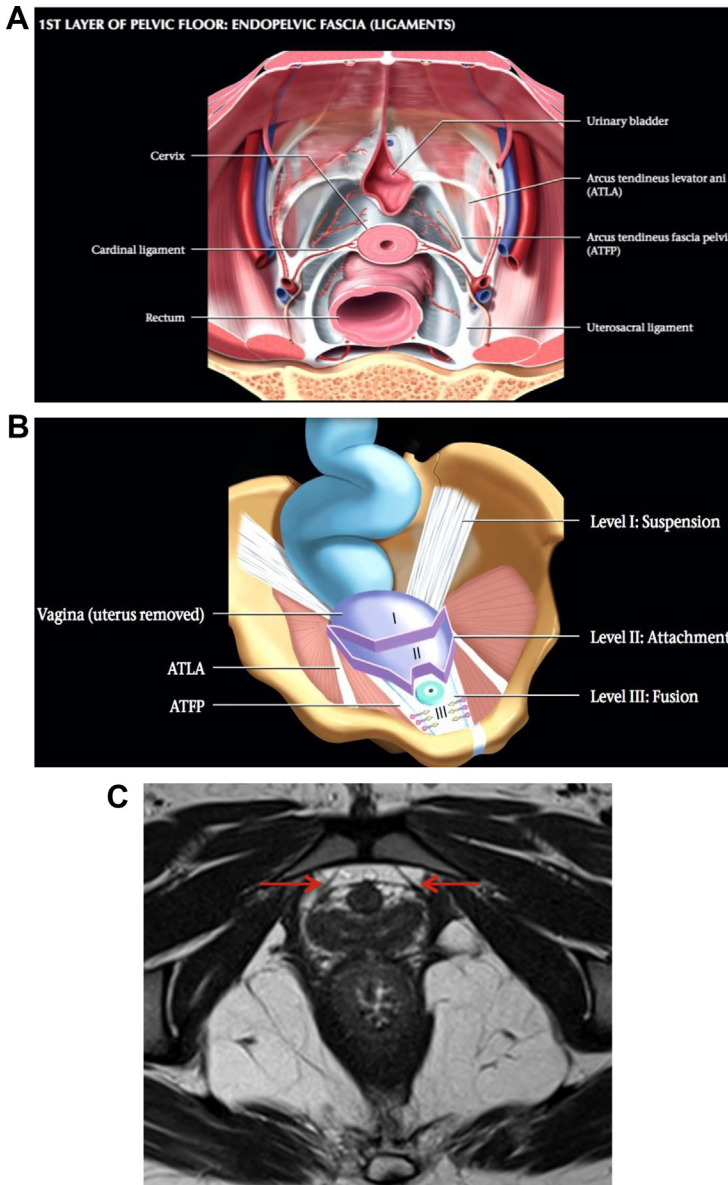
(A) Overview of the pelvis shows the fascia with the bladder, cervix, and rectum cut away. Endopelvic fascia is a continuous adventitial layer, covering the pelvic diaphragm and viscera. It is a complex network of connective tissue composed of collagen, fibroblasts, elastin, smooth muscle cells, and neurovascular bundles. Ligaments are a more well-defined aggregate of connective tissue. (B) The type of support the vagina receives at each level (uterus removed). In level I (suspension), the paracolpium suspends the vagina from the lateral pelvic walls. Fibers of level I extend both vertically and posteriorly toward the sacrum. In level II (attachment), the vagina is attached to the arcus tendineus fasciae pelvis and the superior fascia of levator ani. In level III (fusion), the vagina, near the introitus, is fused laterally to the levator ani. (C) Axial oblique T2WI TSE MR image shows the arcus tendineus fascia pelvis (ATFP) (arrows) on either side of the symphysis pubis. (From [(El Sayed RF. Overview of the Pelvic Floor. In: Shaaban AM, Editor. Diagnostic Imaging: Gynecology 2nd Edition. Philadelphia: Elsevier-Amirsys; 2015. 8/2 -8/28 ; with permission.)
